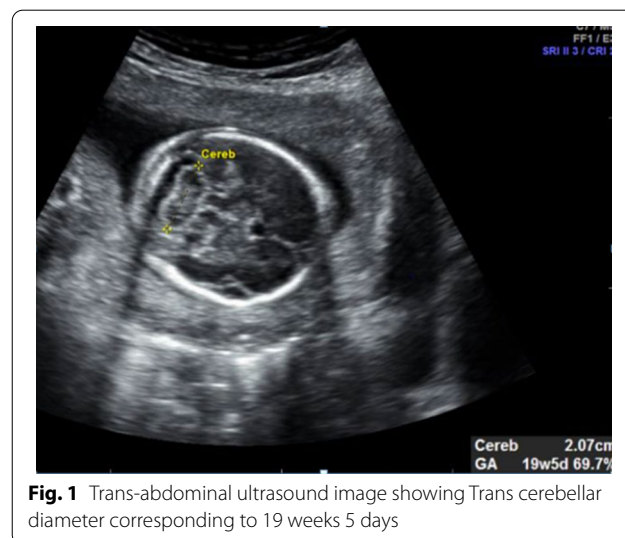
Trans-abdominal ultrasound image showing Trans cerebellar diameter corresponding to 19 weeks 5 days
